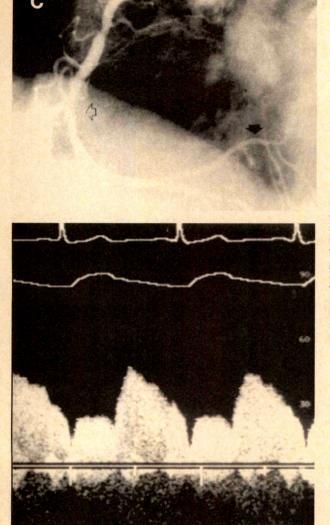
A: Anglogram (top) demonstrating 95% stenosis of the mid-right coronary artery (solid arrow) and corresponding flow velocity pattern (bottom). Velocity scale is 0–160 cm/sec. Note the diminished diastolic/systolic flow velocity ratio. Open arrow shows distal position of Doppler guide wire. B: During balloon inflation, Doppler flow velocity is reversed with a maximum velocity of –25 cm/sec; this pattern was reproducible. C: Flow velocity is normalized after completion of successful angioplasty. Note large posterolateral branch (solid arrow) that was input source of collateral flow. APV = average peak velocity. (Reprinted with permission from Am Heart J.²²)
